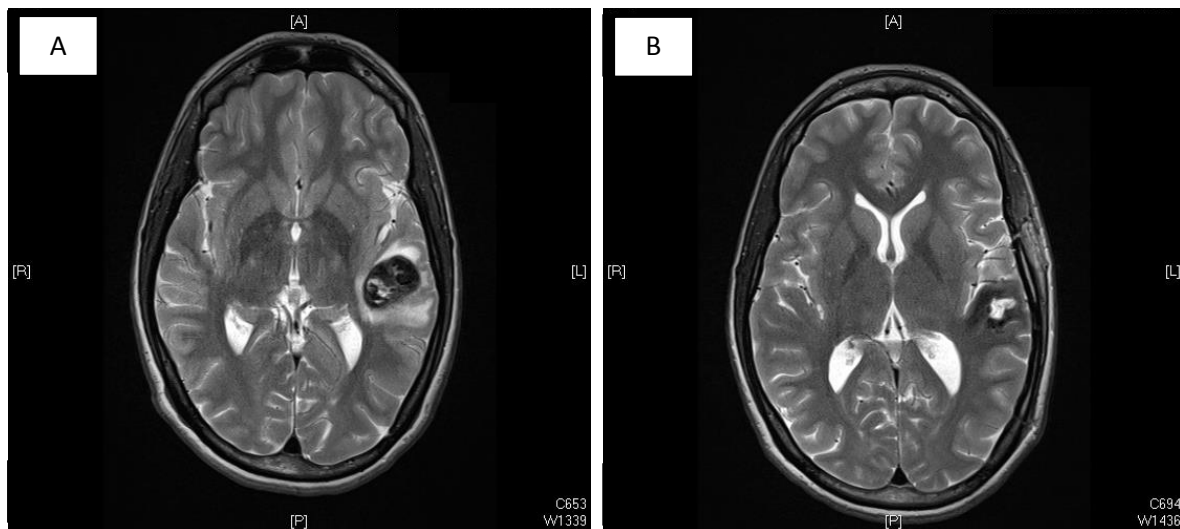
MRI scan, T2-axial, after the third stroke (A) and 2 months after surgery (B).
